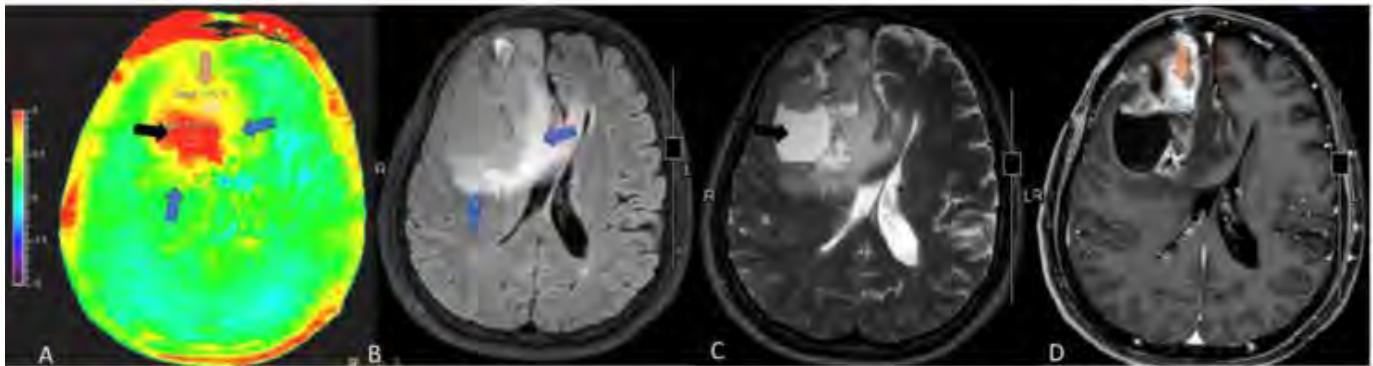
APT-weighted and conventional MR images of a 62-year-old male with glioblastoma at right frontal lobe. APT color map (A) showed yellow color corresponding with the enhancing solid portion in Gd-enhanced T1W-image (D) (orange arrow). Necrotic portion (black arrow) showed red color on APT color map (A) with turbid fluid SI on FLAIR image (B) and high SI on T2W image (C). Two peritumoral hyperintense FLAIR regions showed yellow color on APT color map (A) (blue arrow) comparing to background green color of normal white matter.
